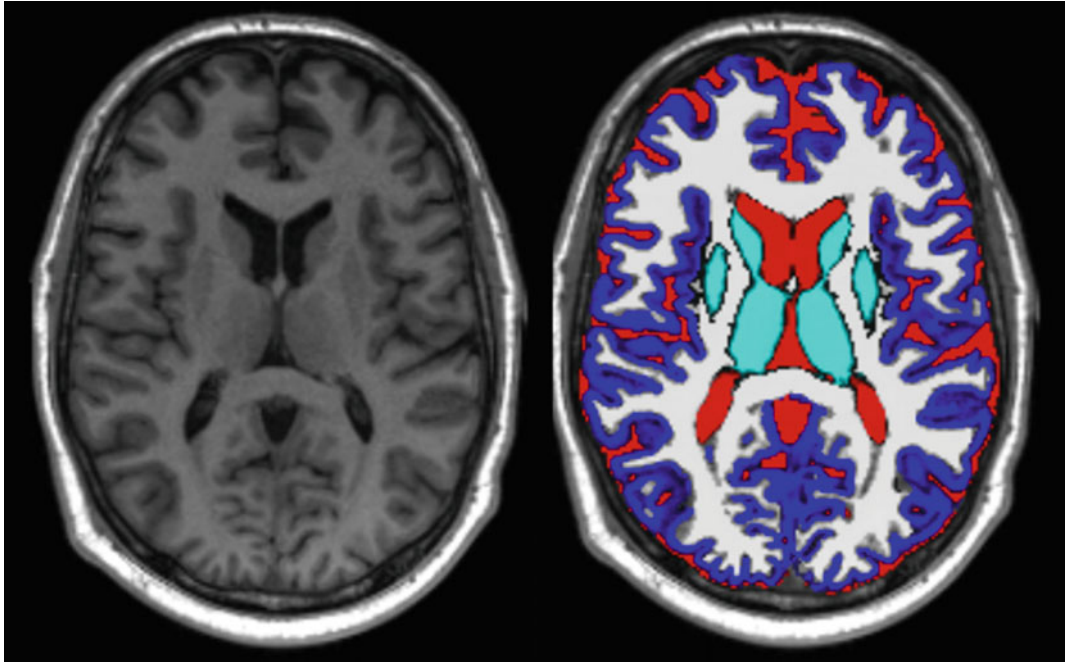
Cerebrospinal fluid (red), cortical grey matter (royal blue), subcortical grey matter (cyan), and normal appearing white matter (white) volume segmentations from T1 MRI (left panel)
